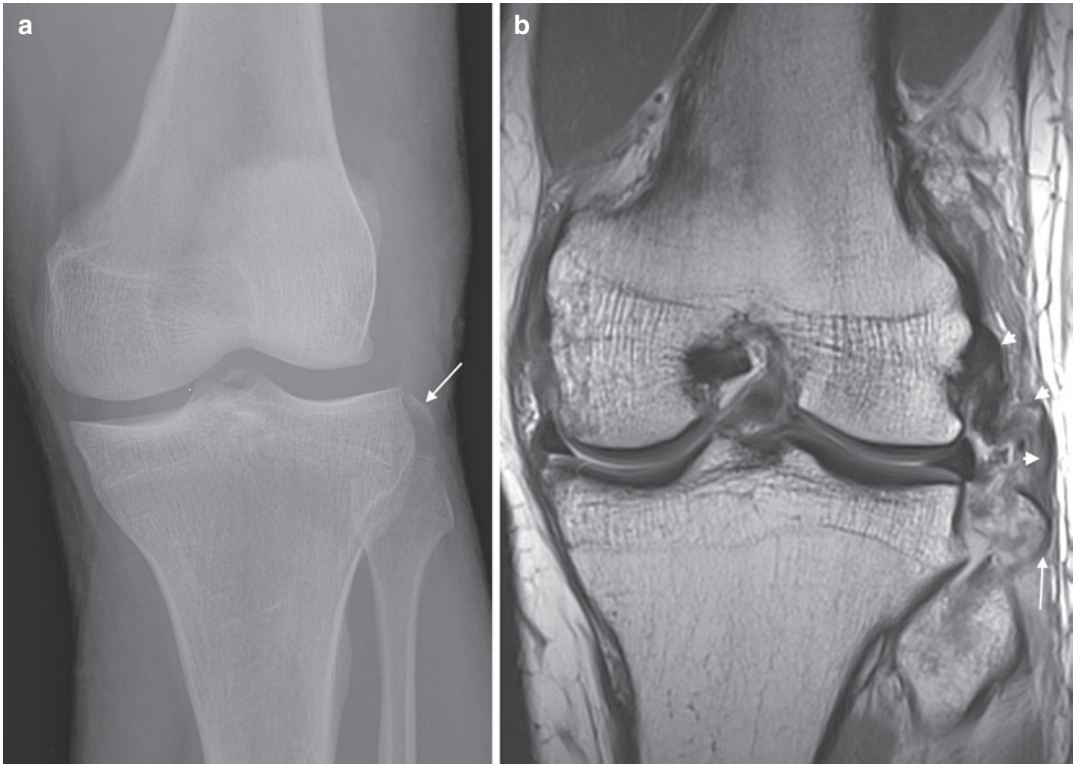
Rupture of the FCL (arrow) on coronal fat-saturated proton density MR image. Note the associated tear of popliteus tendon (arrowhead) and cruciate (asterisk)
